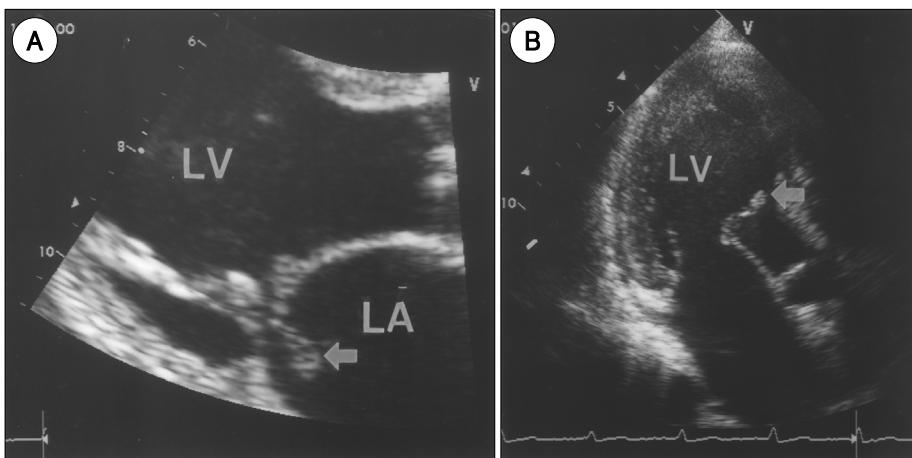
Transthoracic echocardiography in the parasternal long axis (A) and apical views (B) showing the ruptured head of the antero-lateral papillary muscle (arrow) and attached cord. LA: left atrium, LV: left ventricle.
